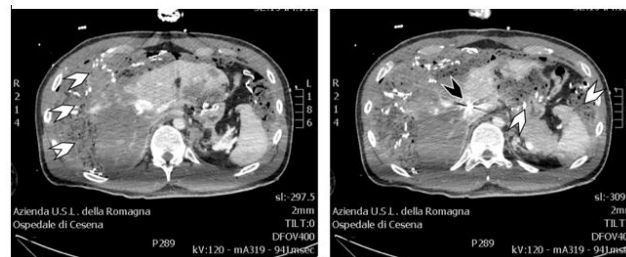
Abdomen CT scan showing massive hepatic injury without active bleeding. Black arrow: embolization coil in right hepatic artery. White arrows: packing gauzes around liver and spleen.
